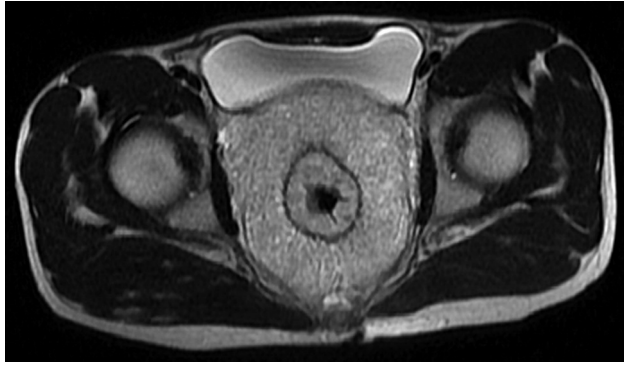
Axial T2-weighted image of the rectosigmoid colon wall and perirectal mass shows high signal intensity.
